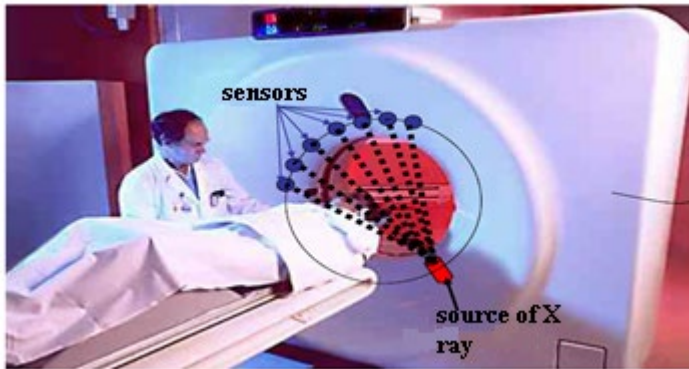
Emission scanner of X-rays
